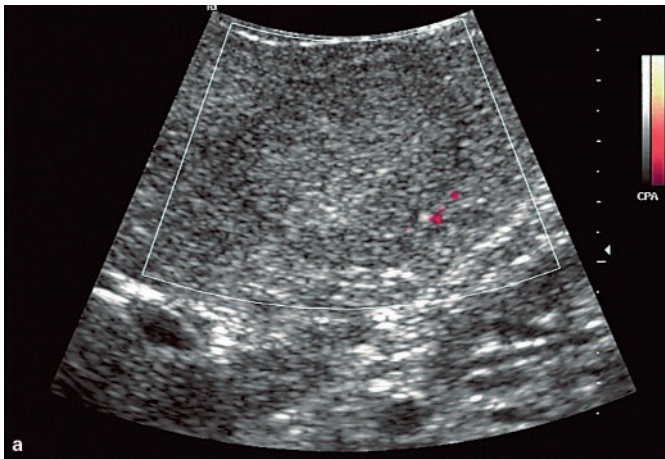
Liver metastasis of a small bowel neuroendocrine tumour at unenhanced (a) and echo-enhanced sonography (b, c). a Hypoechoic lesion with a lobulated margin. b Detection of a hypervascularised mass at the capillary phase 30 s after injection of the echo-enhancer. c Detection of a contrast defect at the portal venous phase 40 s after injection of the echo-enhancer.
